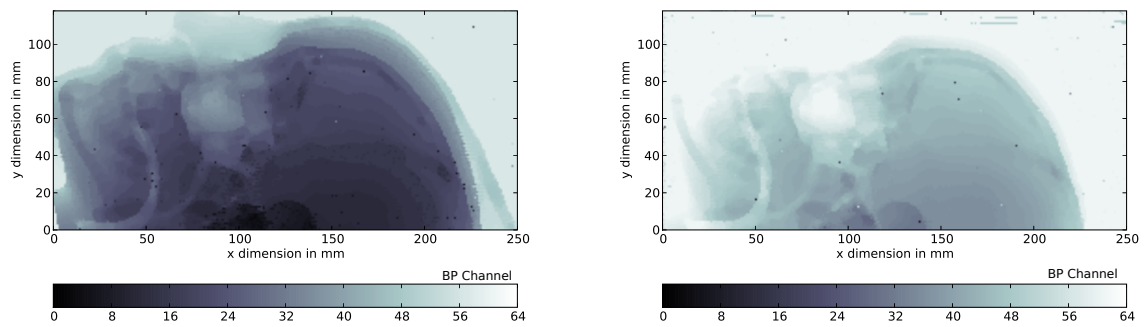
Radiographic images of the Alderson head obtained at 324.26 MeV/u, 3.8 mm FWHM spot size (left) and 416.73 MeV/u, 3.4 mm FWHM spot size (right) using the criterion of maximum identification method to locate the Bragg peak position. The right image shows burned-out regions where the peak fell beyond the ICs stack due to the higher beam energy.
